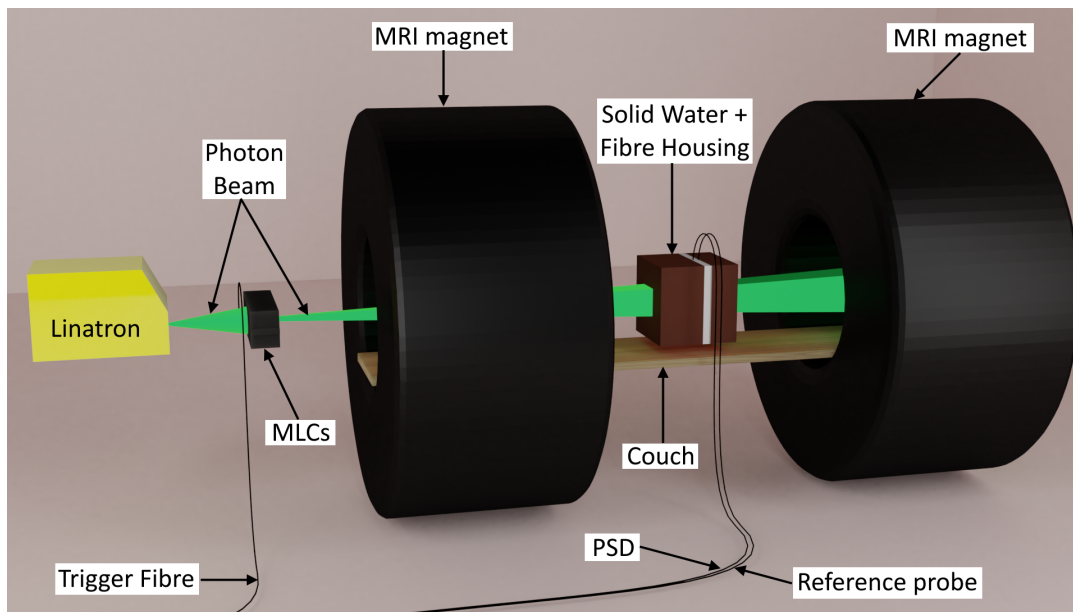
3D model showing the Australian MRI-LINAC and the Solid Water setup used by the in-house PSD for the measurement of output factors and PDDs. Published in Madden *et al.* 2021 [188].
